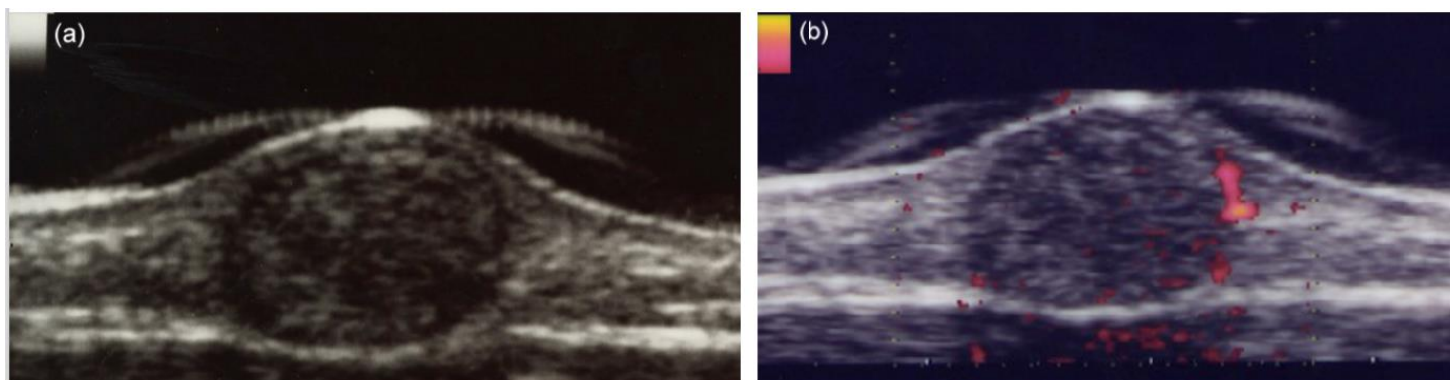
(a) Epidermal cyst on the right upper extremity in a 70s female. A heterogeneous, hypoechoic nodule with dermal attachment and peripheral rim was shown on gray-scale US. (b) Power Doppler US partially showed blood flow signal in periphery.
